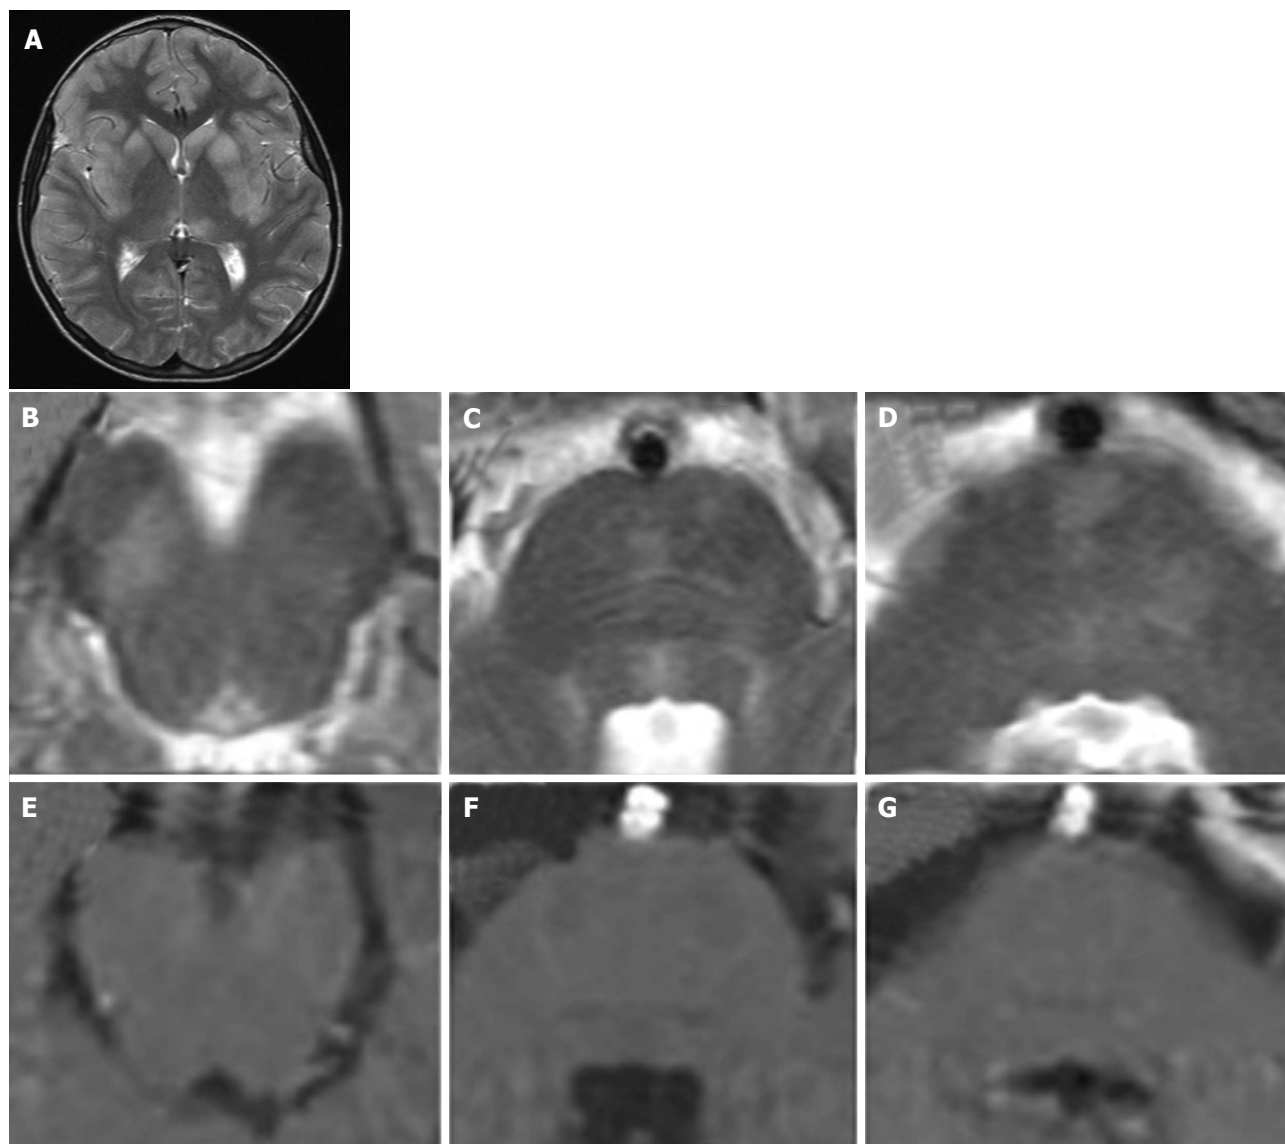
Central pontine myelinolysis. A 11-year-old boy with lymphoma after a rapid correction of hyponatremia. Axial T2-weighted (A and B) and T1 weighted (C and D) images show signal alterations of the central pons. Note the incomplete trident shape and the sparing of the peripheral zones of the pons. Two years later, MR images (E to H) show minimal residual pontine alterations with absence of symptoms.
